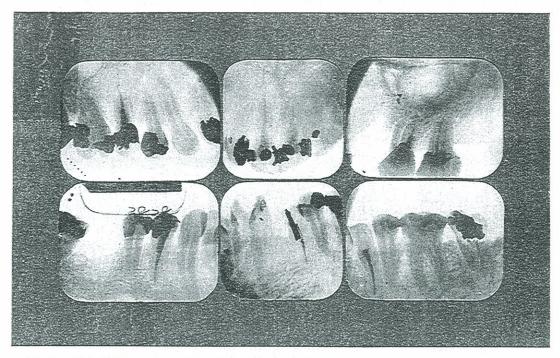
ROENTGENOGRAPHIC APPEARANCE OF TEETH OF CASE NO. 335, WITH HYSTERIA AND LASSITUDE. SEE NEXT FIGURE.
